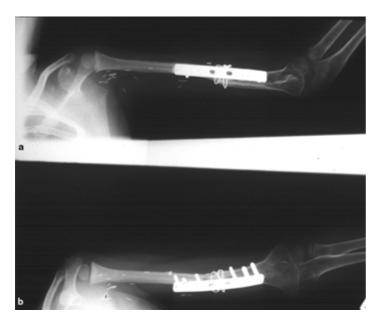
Radiographic view at two years of the reconstructed fibula
